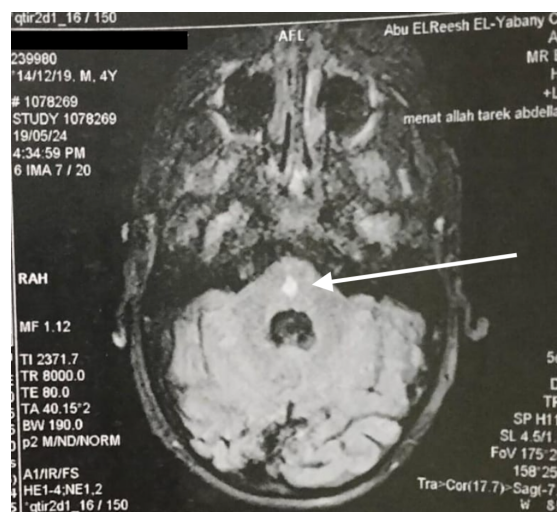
MRI brain , axial cut show multiple pontine foci of altered signal (high abnormal in T2).
